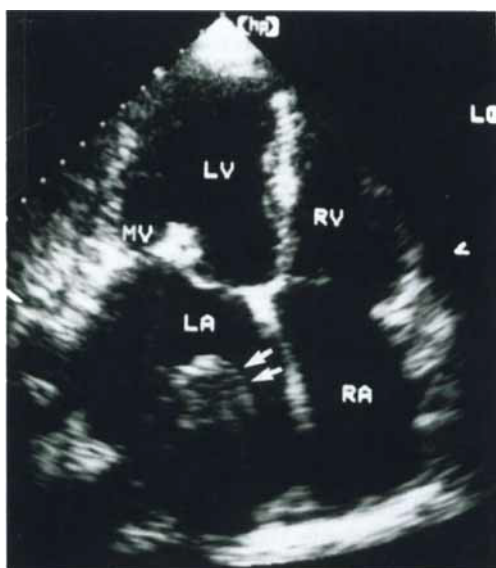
Apical four-chamber view shows huge echogenic density (arrow) suggestive of thrombi located at the posterolateral aspect of the left atrium.
